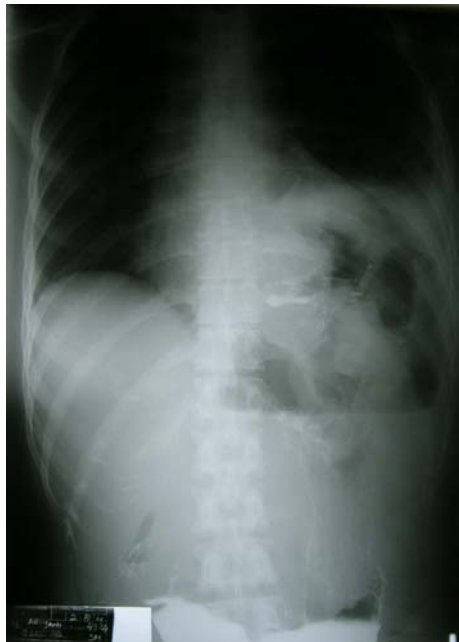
Chest X-ray: Suspicion of Chilaiditi's sign, differential diagnosis lower left lung abscess
